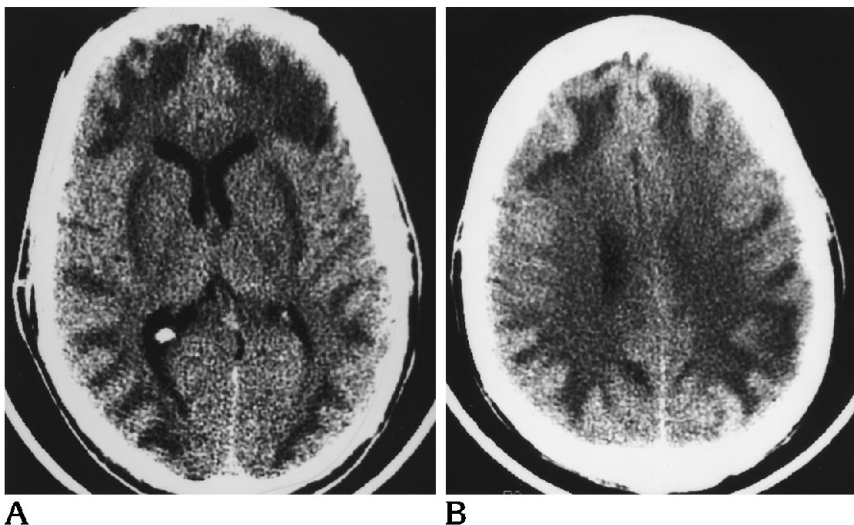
A, CT scan at the level of the basal ganglia 17 days after methanol ingestion shows mainly peripheral white matter lesions and hypodensities that might be located in either the putamina or external capsules.
